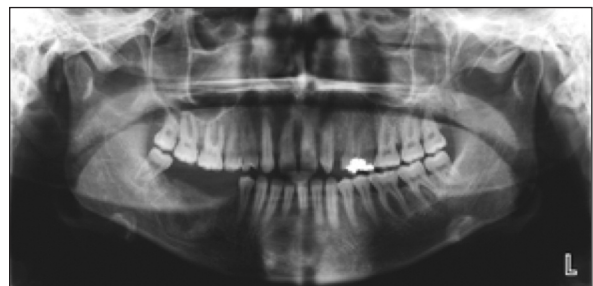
At six months follow-up panoramic radiography demonstrates well defined radiopaque-radiolucent lesion.
